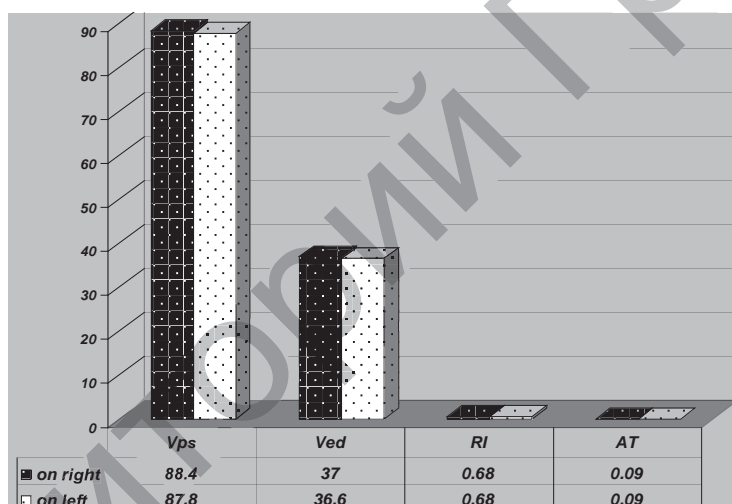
Results of Doppler investigation of right and left renal arteries
